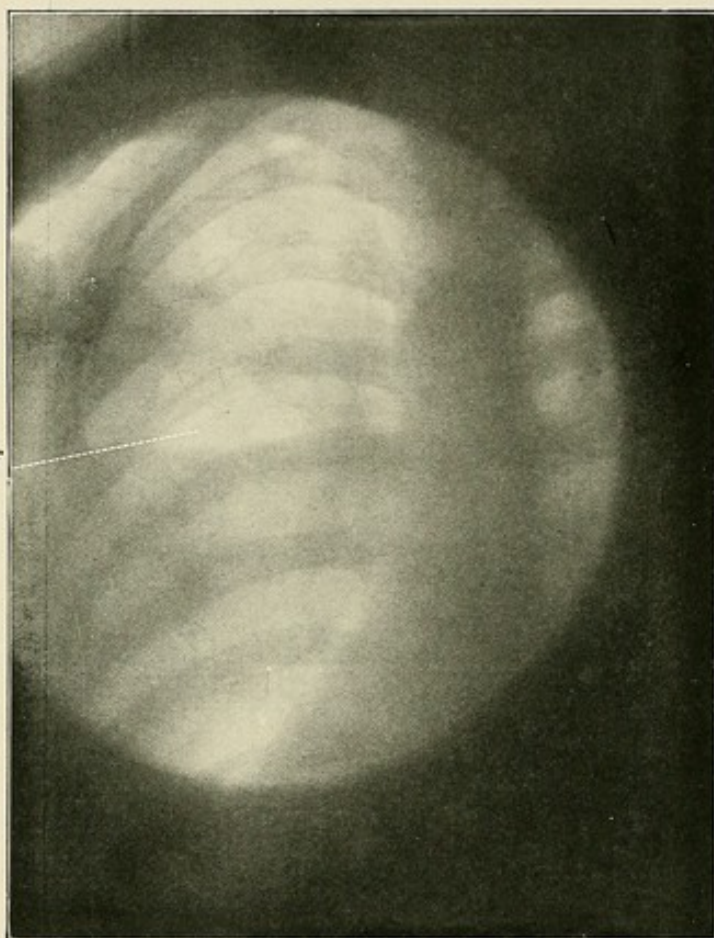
Metapneumonic abscess situated in almost normal pulmonary tissue, and therefore only recognizable by the use of X-rays. The horizontal level of the fluid (f) clearly recognizable; operated upon, died of after-hæmorrhage into the cavernus. Ventrodorsal.
